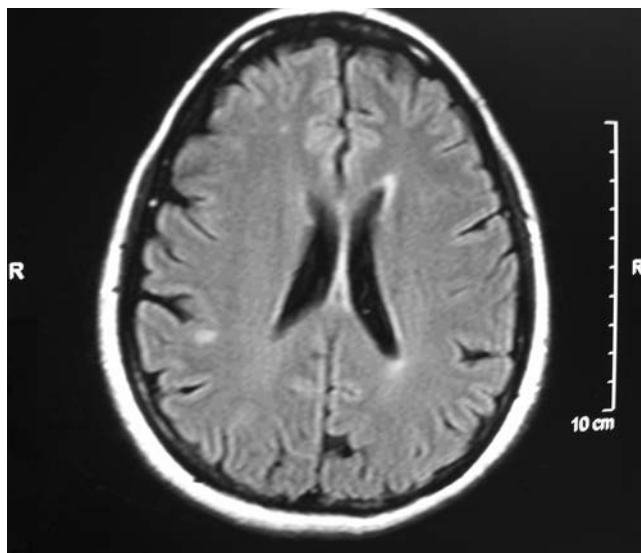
MRI of a 53-year-old woman with a long history of migraine. FLAIR sequences. The size and location of the white matter lesions are relatively nonspecific and are atypical for demyelinating disease.
